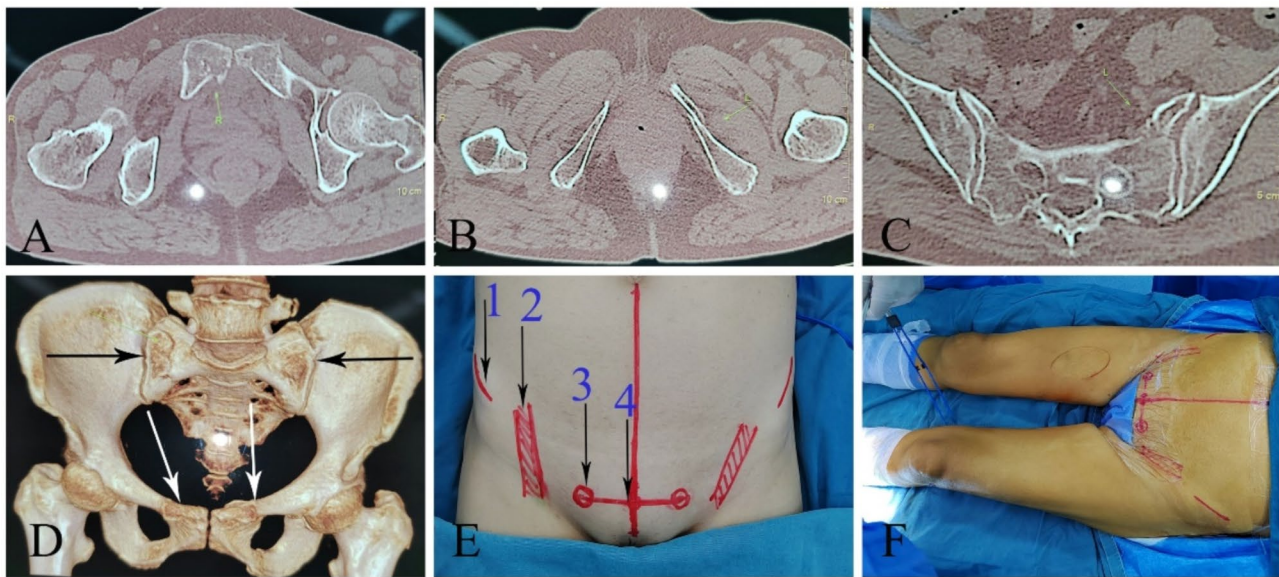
A-D: (A-C) axial and (D) three-dimensional CT reconstruction pelvic radiographs showed bilateral pubic ramus fractures with anteroposterior displacement (white arrows) and sacroiliac joint injury (black arrow). E: Identified surgical landmarks and planned incisions. (1, ASIS; 2, the pulse region of femoral artery, vein, and nerve; 3, iliopubic eminence; 4, pubic tubercle). F: The surgical manipulation area and ipsilateral lower limb of disinfection, draping, and affixed incision membrane. ASIS, anterosuperior iliac spine
